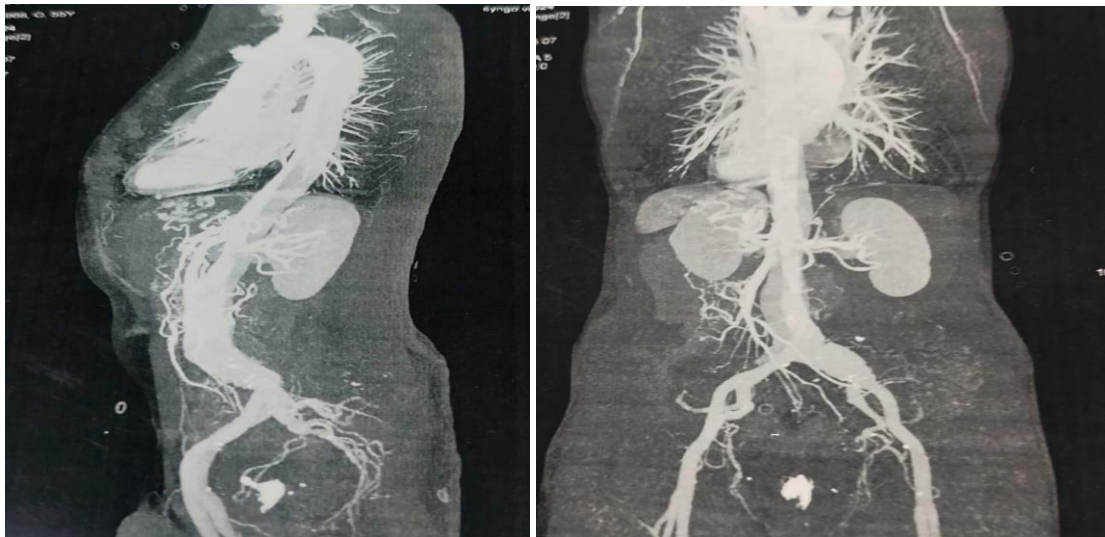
Thoraco-abdominal CT angiography, 3D reconstruction, coronal and sagittal planes: appearance of an aortic dissection involving the ascending aorta, the aortic arch, the descending aorta, as well as the supra-aortic trunks, with no evidence of pericardial effusion
